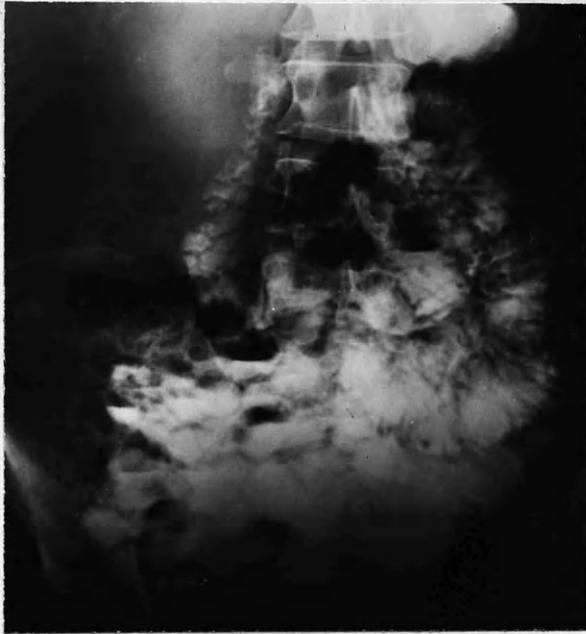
PATIENT 69 AFTER POLYA GASTRECTOMY. RADIOGRAPH 30 MINUTES AFTER INGESTION OF 200 ml. RAYBAR-GLUCOSE SHOWING FLUID LEVELS IN SMALL BOWEL. NO "DUMPING" SYMPTOMS OCCURRED.
